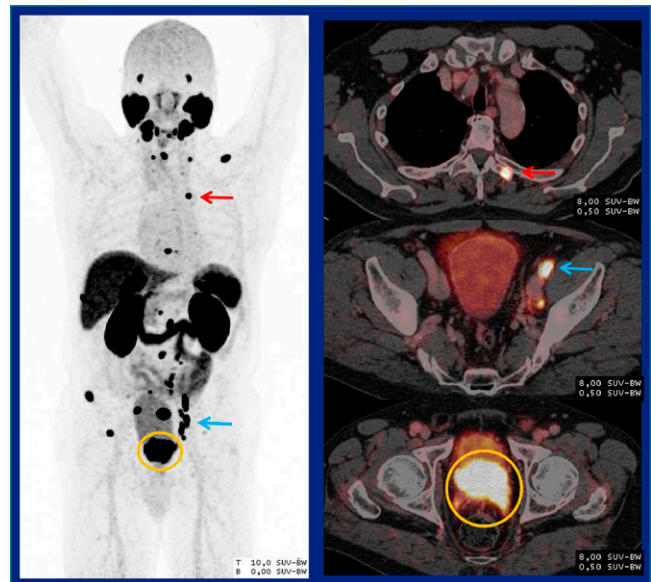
Left: Representative imaging from the  $^{68}\text{Ga}$ -PSMA-11 PET/CT trial from UCLA and an international consortium. Right: Representative imaging from the CONDOR phase III  $^{18}\text{F}$ -DCFPyL PET/CT trial. Despite difference in enrollment criteria and procedures, common findings included higher overall detection rates that correlated with increasing prostate-specific antigen levels, good positive-predictive values, and improved sensitivity. Reader agreement results were also high with both tracers.
